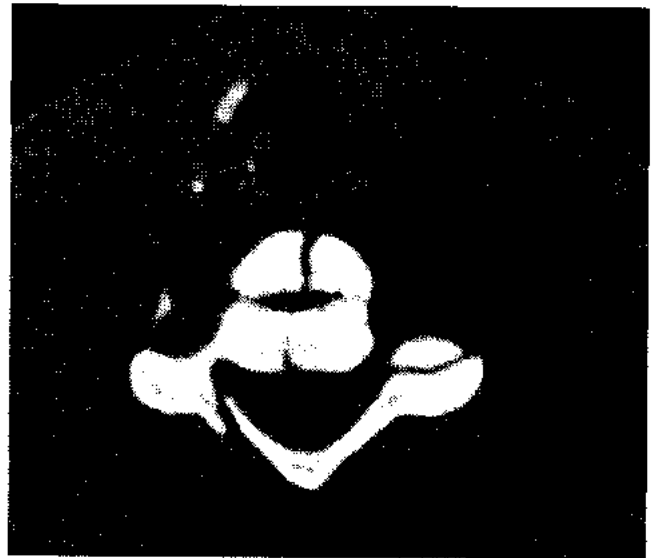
Computed tomography scan of C5 vertebral body, burst fracture. Note the destruction of the vertebral body and minimal disruption of the posterior aspect of the vertebral body. The lamina is also fractured.
